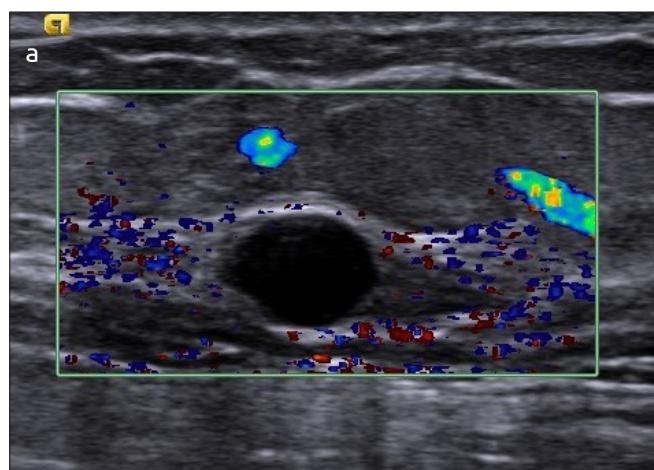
a, b. (a) Ultrasound of the left breast: Superficially located well defined cyst-like avascular round lesion. (b) Second US examination revealed the solid nature of the nodule and an echogenic halo
